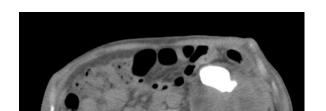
abdominal contrast CT
